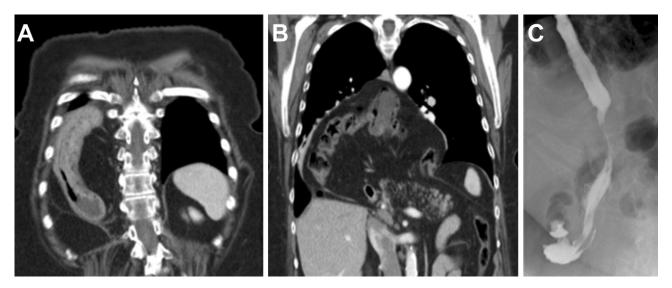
(A and B) Coronal computed tomography scan images of a patient with a type IV hiatal hernia. (C) Barium esophagogram after laparoscopic repair with wedge gastroplasty.
